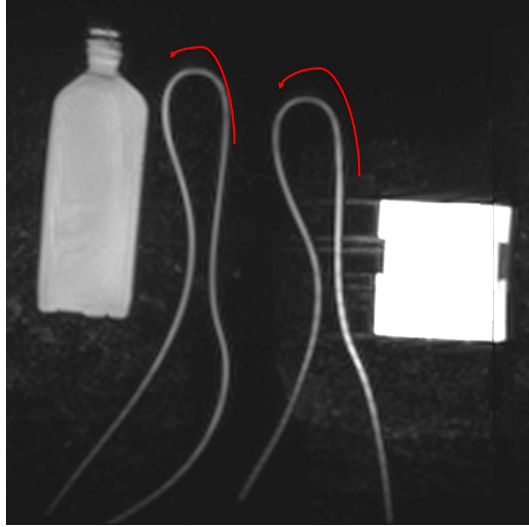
Top view of the set-up inside of the MRI. Left to right: bottle 1, tube 4, 3, 2 and 1; and bottle 2. The arrows indicate the direction of the flow through the tubes.
